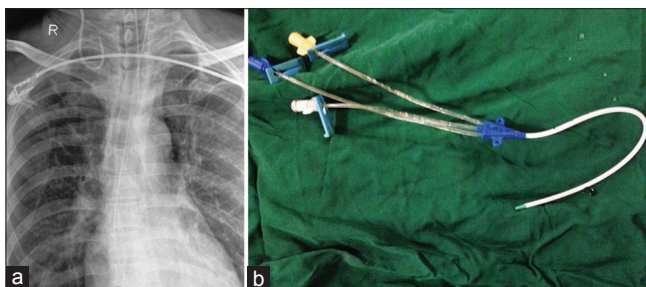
(a) Chest X-ray anteroposterior view with coiled central venous catheter in right internal jugular vein, (b) Coiled central venous catheter after removal
